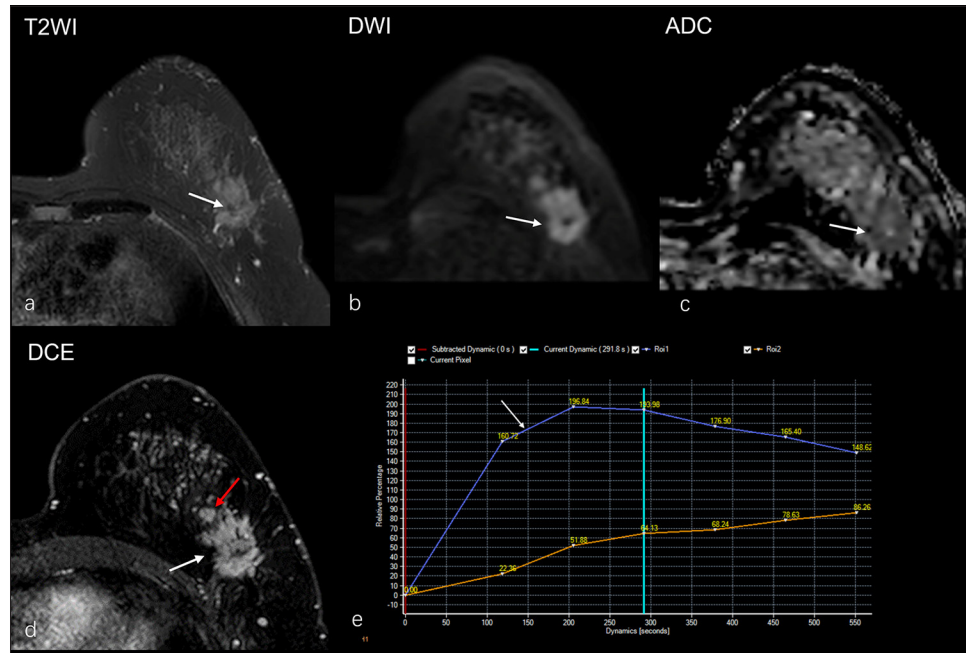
A 52-year-old woman diagnosed with invasive ductal carcinoma of the Luminal B subtype. (a) The lesion presents uneven low signal on T2-weighted imaging (white arrow), (b) uneven high signal on diffusion-weighted imaging (white arrow), (c) corresponding low signal on apparent diffusion coefficient (ADC) mapping (white arrow), the average ADC value is $0.72 \times 10^{-3} \text{mm}^2/\text{s}$. (d) The initial phase of dynamic contrast enhancement shows a heterogeneous internal enhanced mass with irregular shape and spiculated margin (white arrow), and a daughter lesion in front of the mass (red arrow), (e) the kinetic curve (white arrow) demonstrates a wash out appearance (type III curve). (T2WI: T2-weighted imaging, DWI: Diffusion-weighted imaging, DCE: Dynamic contrast enhancement)
